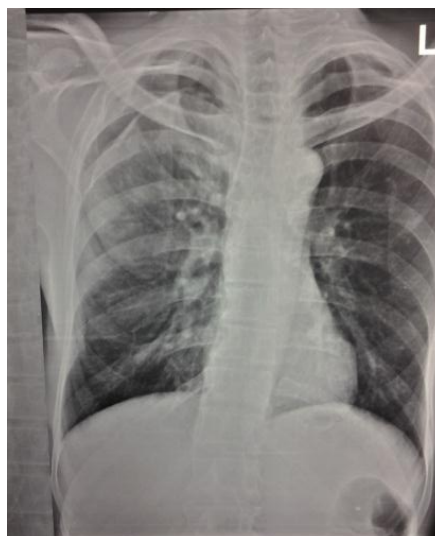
The patient's chest radiographs show comparatively poor ventilation of right lung. The angles of the lungs are well defined
